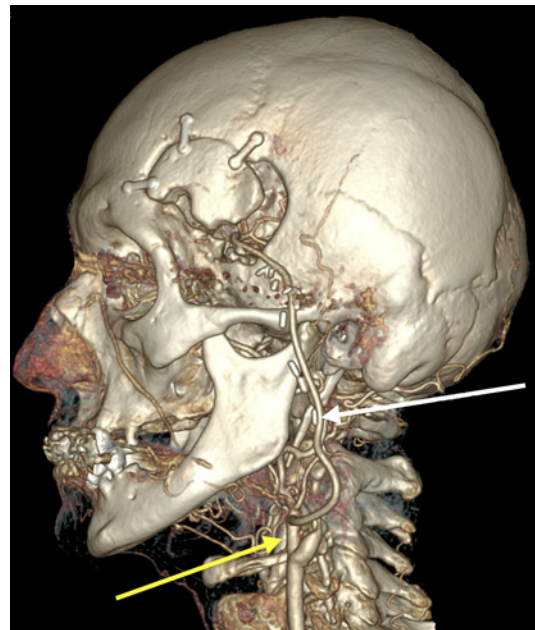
CTA; 3D reconstruction shows filling of the left ICA and high-flow bypass.
